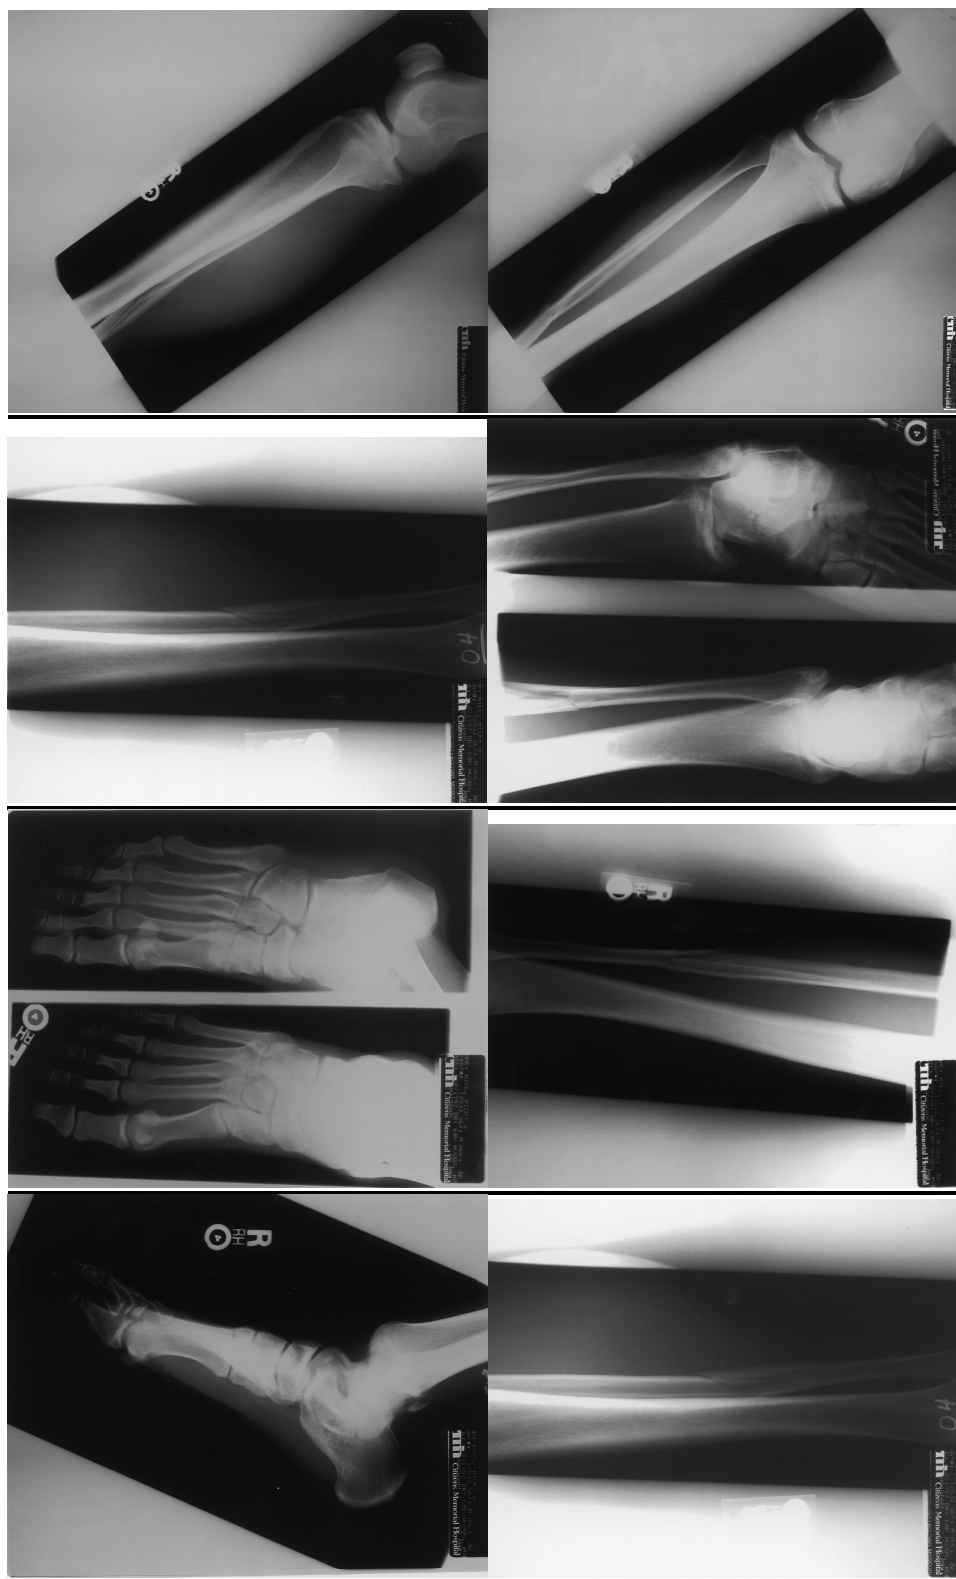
Radiographs from PWC File 5.
